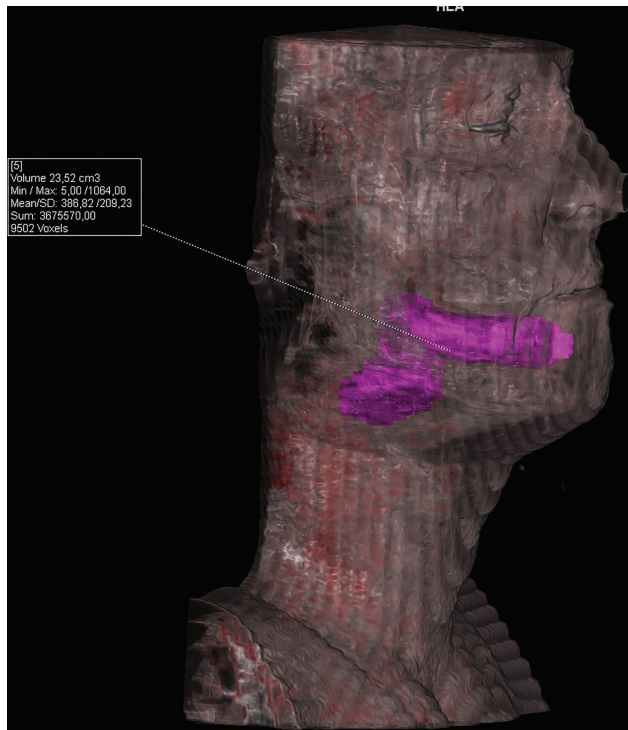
Postoperative MRI with delineation of the radial forearm free flap (purple) using digital marking after complete tumor resection of a patient with oral squamous cell carcinoma (OSCC) in the right mandible. The volume of the flap, including the vessel, was measured to be 23.52 cm³.
